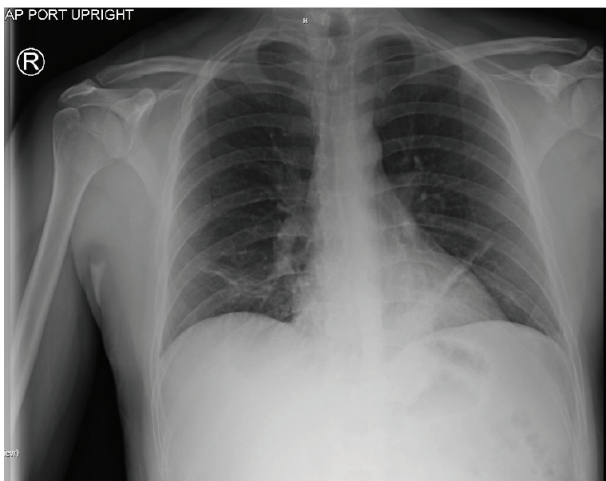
Radiography of the chest revealed atelectasis in right and left lower lobes
